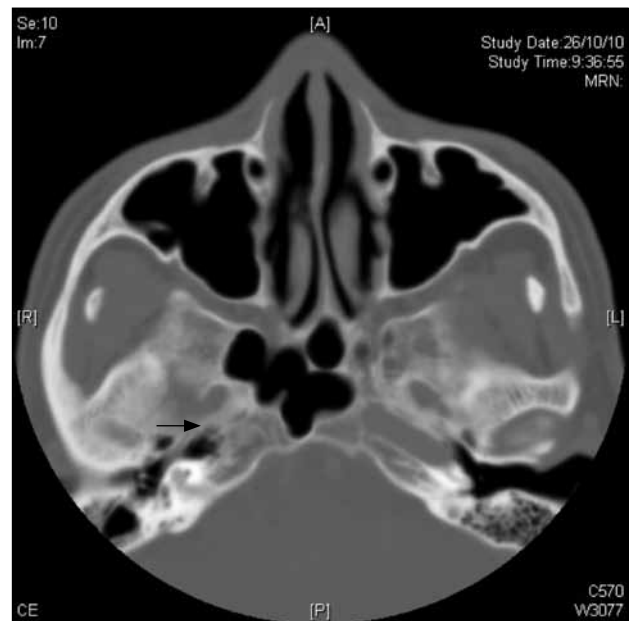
A plain computed tomographic image of the skull base with bone window showing the absent right carotid canal (arrow). The left carotid canal is well visualised.
